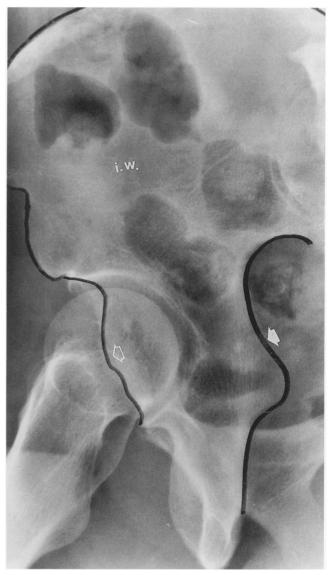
The iliac oblique radiograph demonstrates the iliac wing (i.w.), posterior column (solid white arrow) and the anterior wall (hollow white arrow). The superior portion of the PC is well demonstrated.
